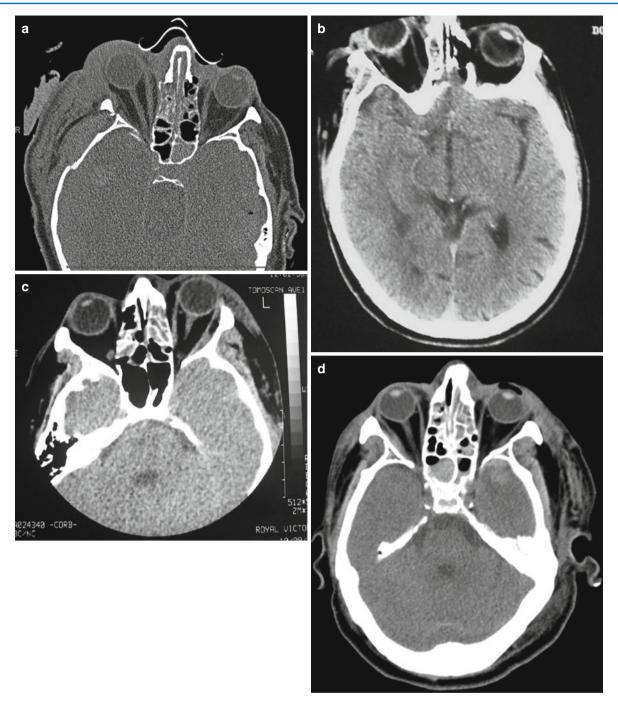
(a-d) Several cases of acute proptosis following trauma. All required urgent computed tomography to evaluate their head injuries. In all cases, the clinical findings were interpreted as a possible retrobulbar hemorrhage. Yet in all these cases there is no blood. This has major implications in cases where there is no imaging available but urgent treatment is necessary. In the last example, stretching of the optic nerve and a tenting of the posterior sclera represent the so-called "balloon on a string" sign
